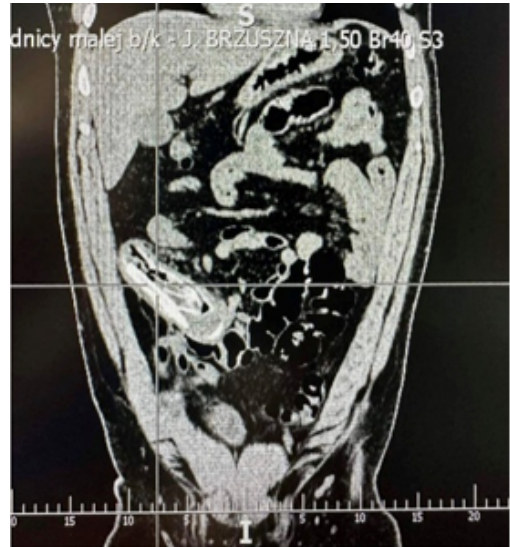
CT of the abdomen, frontal section; lines indicate the IGB.
